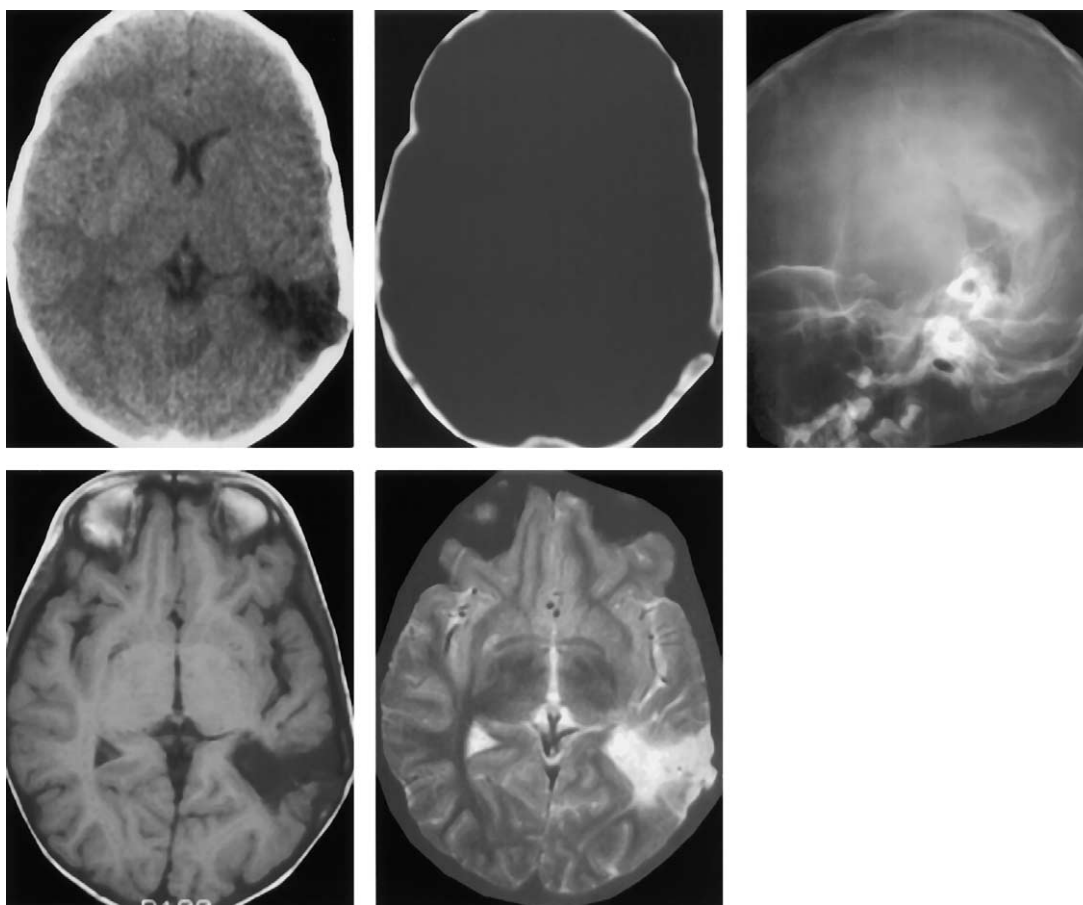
Axial CT scan (*upper left*) demonstrates encephalomalagic area of the left posterior temporal region with obvious lytic defect of the bone best seen on the bone images (*upper middle*). Eburnated margins of the bone of the lytic lesion suggest that this is a chronic lesion. Lateral skull view demonstrates an oblique lesion, typical of the growing fracture (*upper right*). Axial T1- (*lower left*) and T2- (*lower right*) weighted images demonstrate the changes seen on the CT scan and the extensive gliosis in this case. Porencephalic involvement of the ventricular system is noted.
